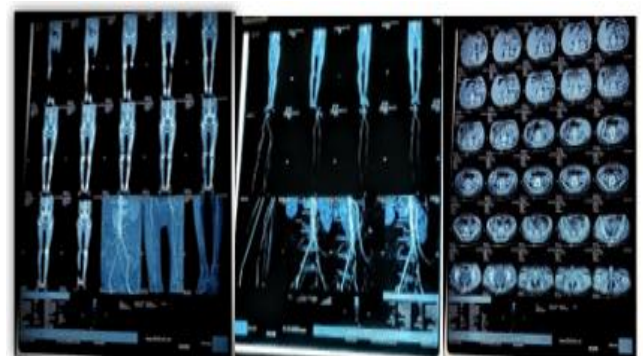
CT angiography of the bilateral lower limbs shows Atherosclerotic disease affects the iliac and abdominal aorta
